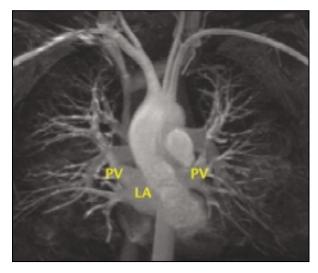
Magnetic resonance imaging (MRI) of the pulmonary veins (PV) and left atrium (LA) in a patient with atrial fibrillation. The variation in size, angulation, and proximal branching pattern of the pulmonary veins is revealed by MRI. Custom slices for each pulmonary vein can be selected to quide the circumferential ablation of each vein and determine when ipsilateral veins have a common
